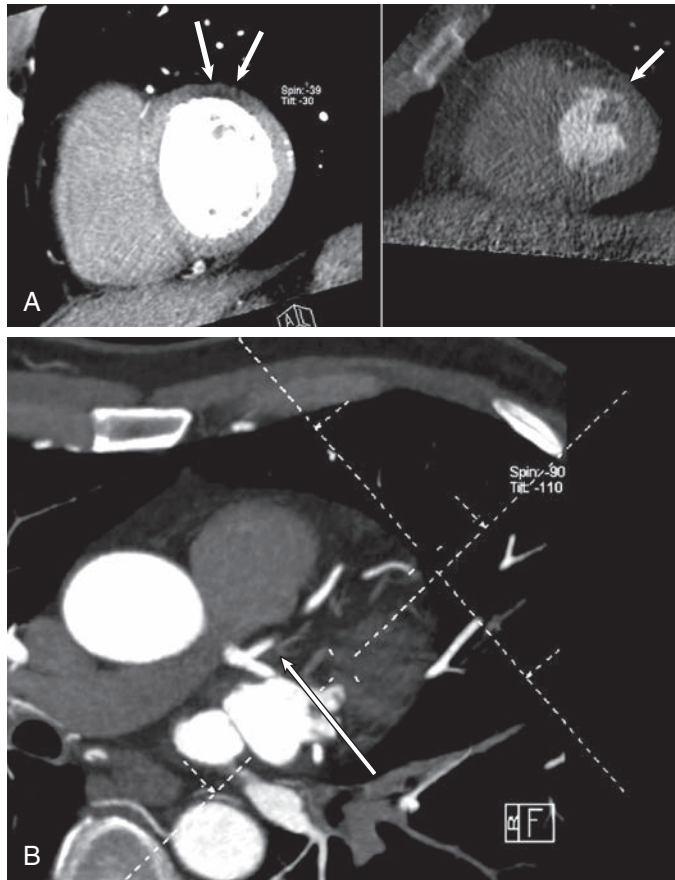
(A) Two-chamber, short-axis view with a narrow “contrast” window used to assess differences in myocardial tissue attenuation. In the anterior myocardial wall, there is a sharply delineated area of low attenuation, representing a perfusion deficit. In cine loops, this appeared to be associated with a hypokinesia by absence of wall thickening in systole of that segment. The patient ultimately developed an increase in cardiac troponin and was diagnosed with non-ST-elevation myocardial infarction (NSTEMI). NSTEMI is often based on occlusions of smaller diagonal or obtuse marginal branches. Hence, highly skilled interpretation of coronary CT angiography is needed to recognize these appropriately. (B) Contrast enhanced coronary CT angiograph displaying the bifurcation of the left main coronary artery. The proximal left anterior descending artery gives rise to a small first diagonal branch (arrow), which appears to be occluded. This finding is easy to miss, leaving myocardial perfusion defect as the sole evidence of an ongoing acute coronary syndrome. Subsequent invasive coronary angiography confirmed proximal occlusion of the first diagonal branch.
